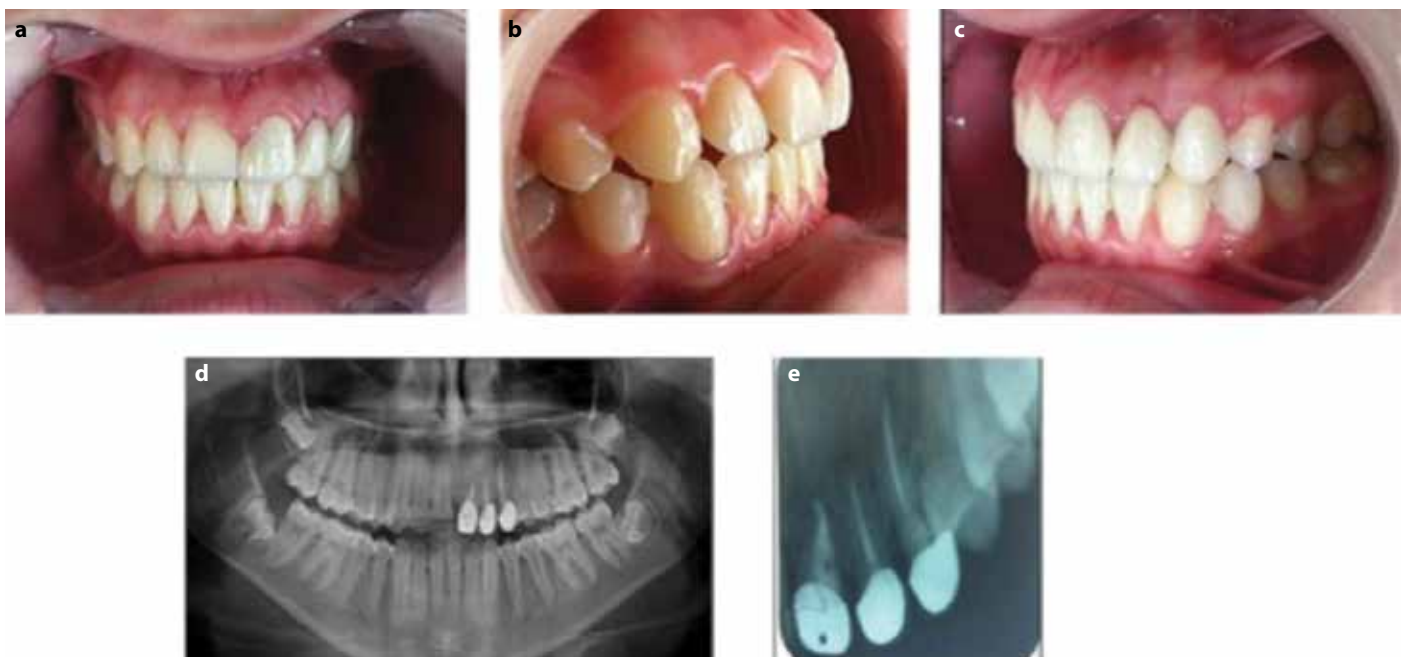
a-e. (a-c) Intraoral (d, e) radiographic view after zirconium crown in 5 year follow-up.
